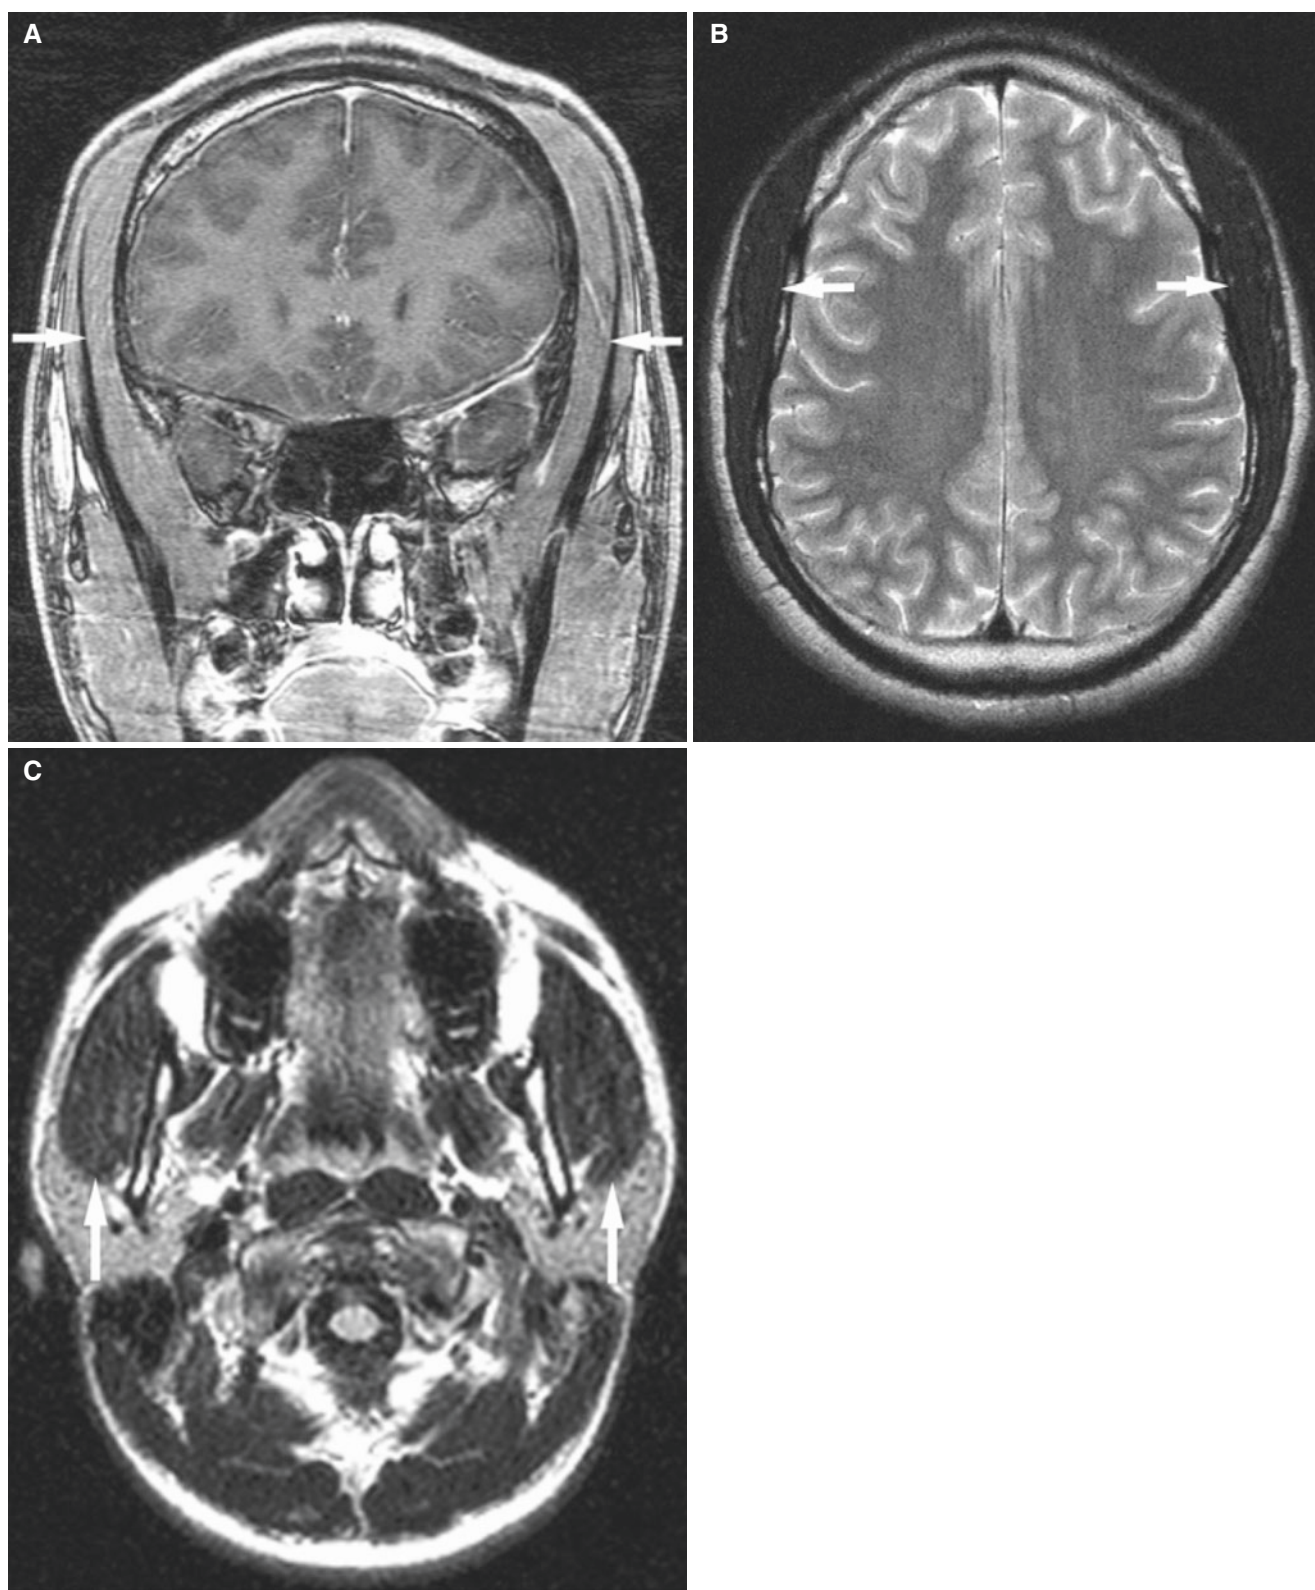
Temporalis hypertrophy and masseteric hypertrophy; 17-year-old male with history of psychosis; no organic causes for his symptoms were found. (A) Coronal T1-weighted MRI shows bilaterally thickened temporalis muscles (*arrows*). (B) Axial T2-weighted
